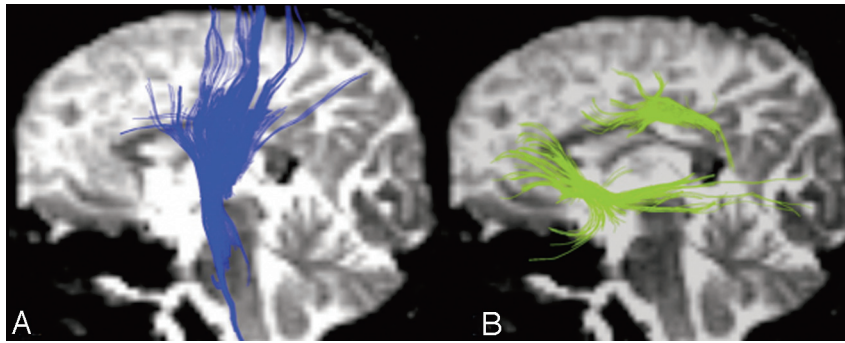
Left lateral view of the 3D reconstruction of projection fibers and LAF on the background of a $b = 0$ T2-weighted image. *A*, Projection fibers. *B*, LAF (SLF, IFOF, and UF) pathway.
